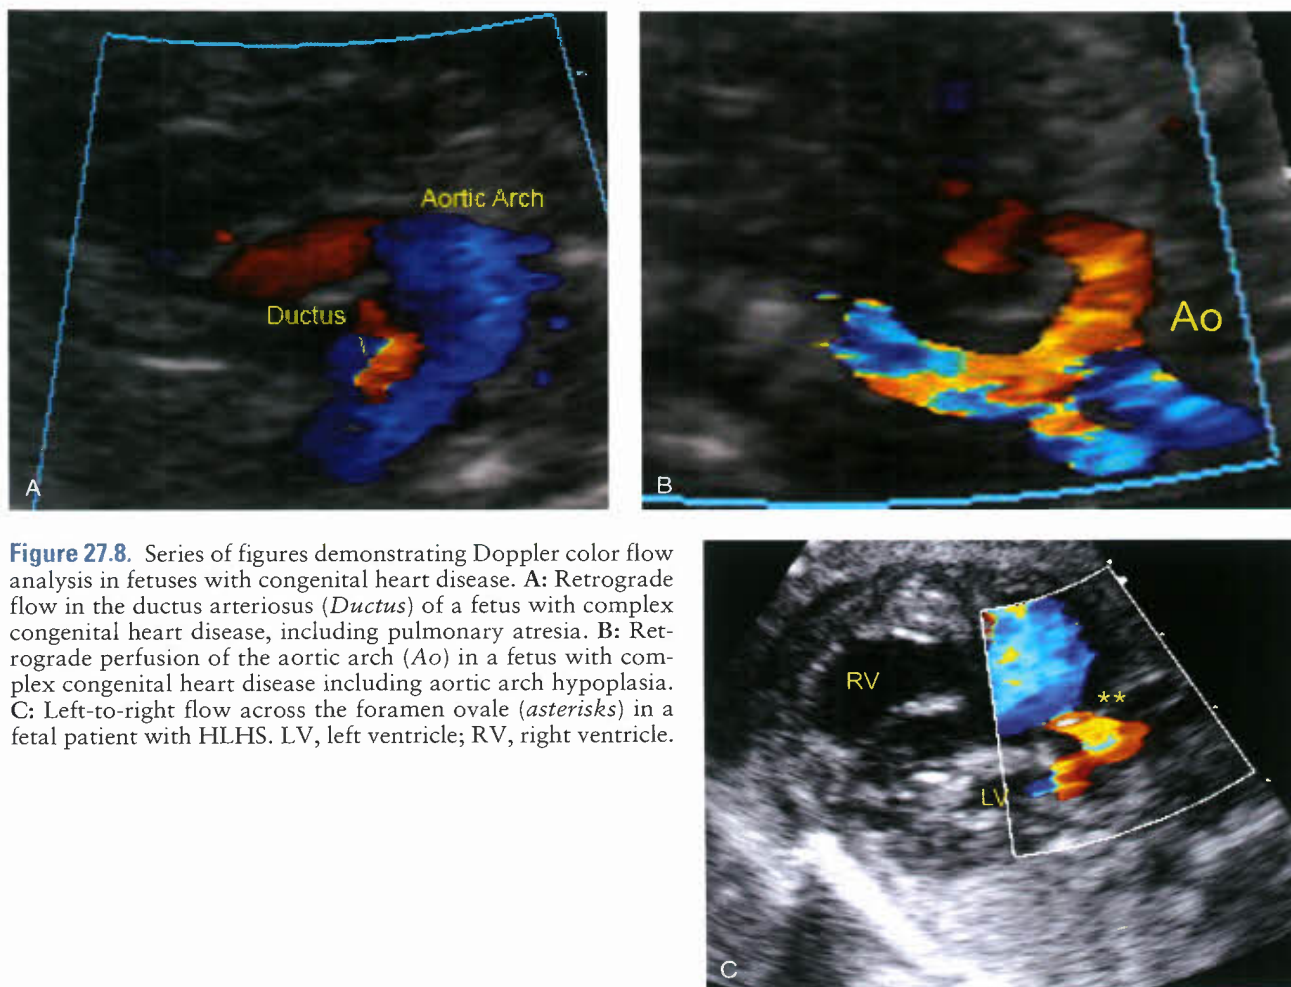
Series of figures demonstrating Doppler color flow analysis in fetuses with congenital heart disease. A: Retrograde flow in the ductus arteriosus (*Ductus*) of a fetus with complex congenital heart disease, including pulmonary atresia. B: Retrograde perfusion of the aortic arch (*Ao*) in a fetus with complex congenital heart disease including aortic arch hypoplasia. C: Left-to-right flow across the foramen ovale (*asterisks*) in a fetal patient with HLHS. LV, left ventricle; RV, right ventricle.
